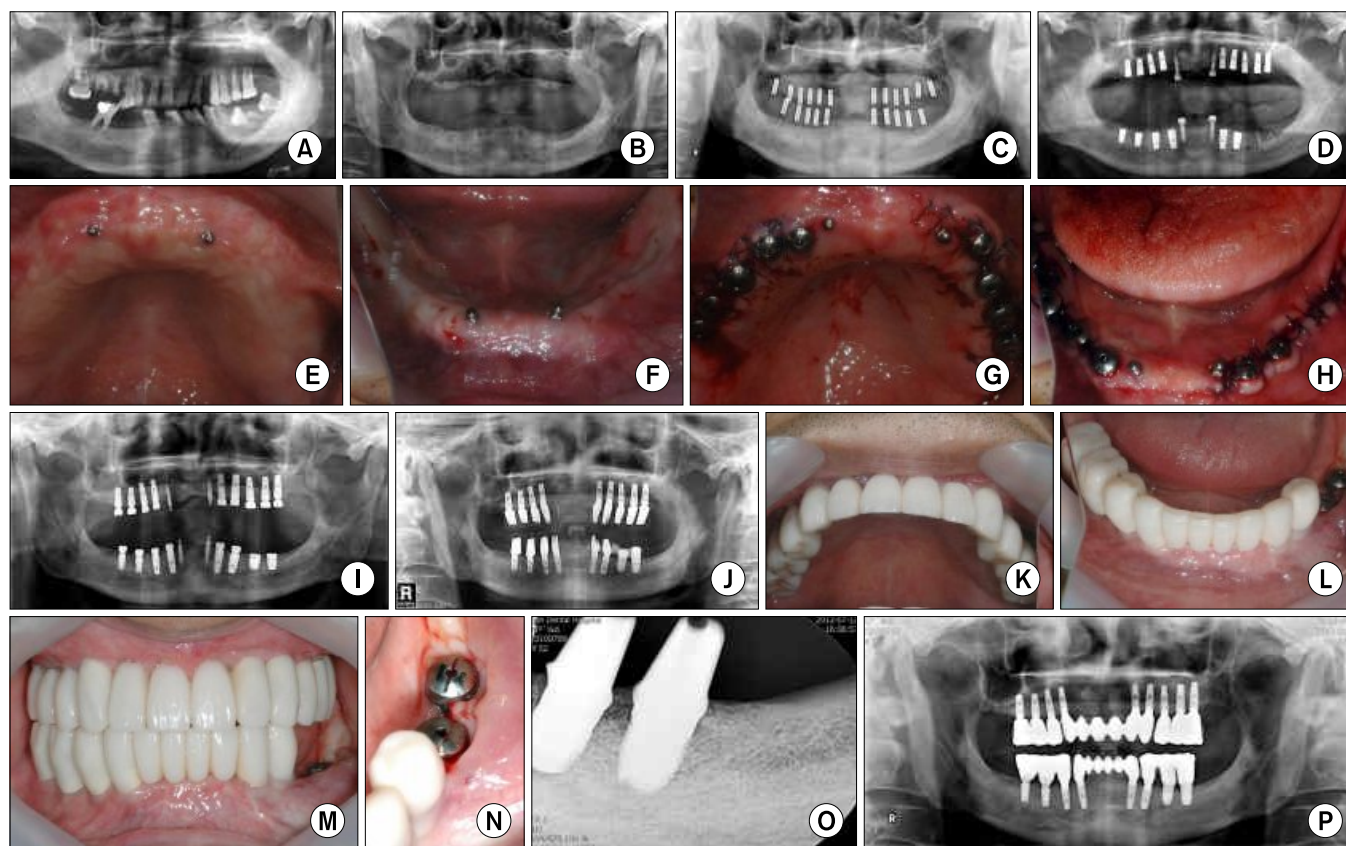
(A) Pre-operation panorama. (B) Post extraction tooth panorama. (C) Surgical stent panorama. (D) Post operation panorama-1st OP. (E) Intra-oral view;post operation 6 month (upper). (F) Intra-oral view;post operation 6 month (lower). (G) Intra-oral view; after 2nd operation (upper). (H) Intra-oral view; after 2nd operation (lower). (I) Post operation panorama-2nd OP. (J) Abutment connection panorama. (K) Intra-oral view; Provisional prostheses (upper). (L) Intra-oral view; Provisional prostheses (lower). (M) Intra-oral view; Provisional prostheses. (N) Additional implants placed on bone graft site. (O) Periapical view; #35, 36 abutment setting. (P) Final prostheses panorama.
